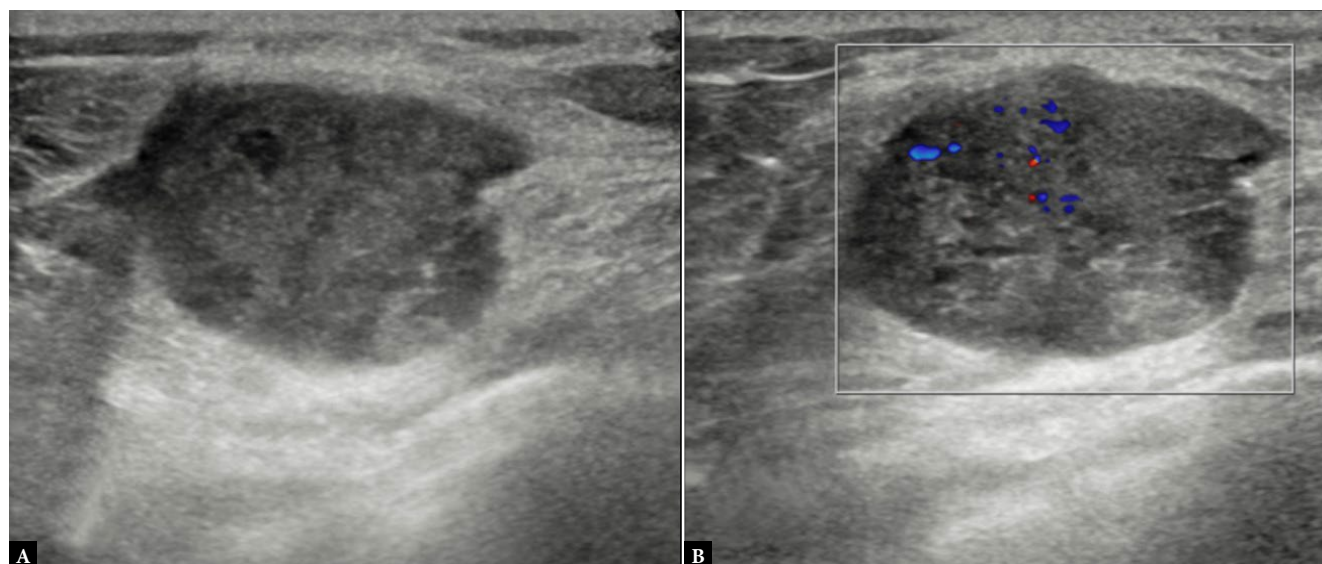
A 48-year-old female with invasive ductal carcinoma and triple-negative molecular subtype of breast cancer. Ultrasound image A. gray scale shows a well-circumscribed hypoechoic mass with macrolobulations and posterior acoustic enhancement B. color Doppler shows internal vascularity
